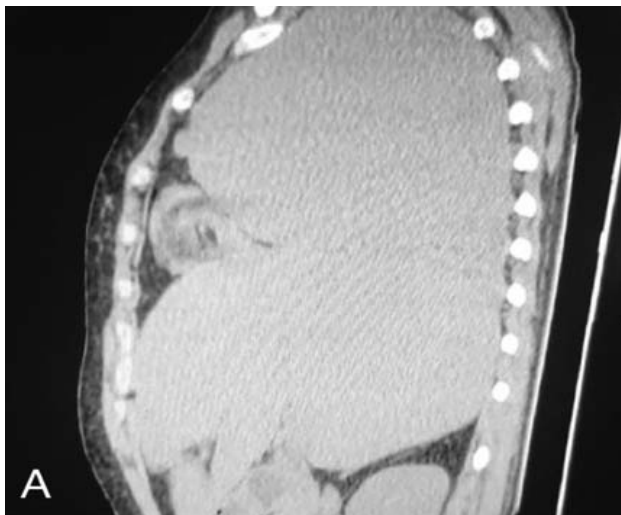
Chest CT sagittal sections with (A) mediastinal precontrast, (B) mediastinal post contrast and (C) parenchymal window
